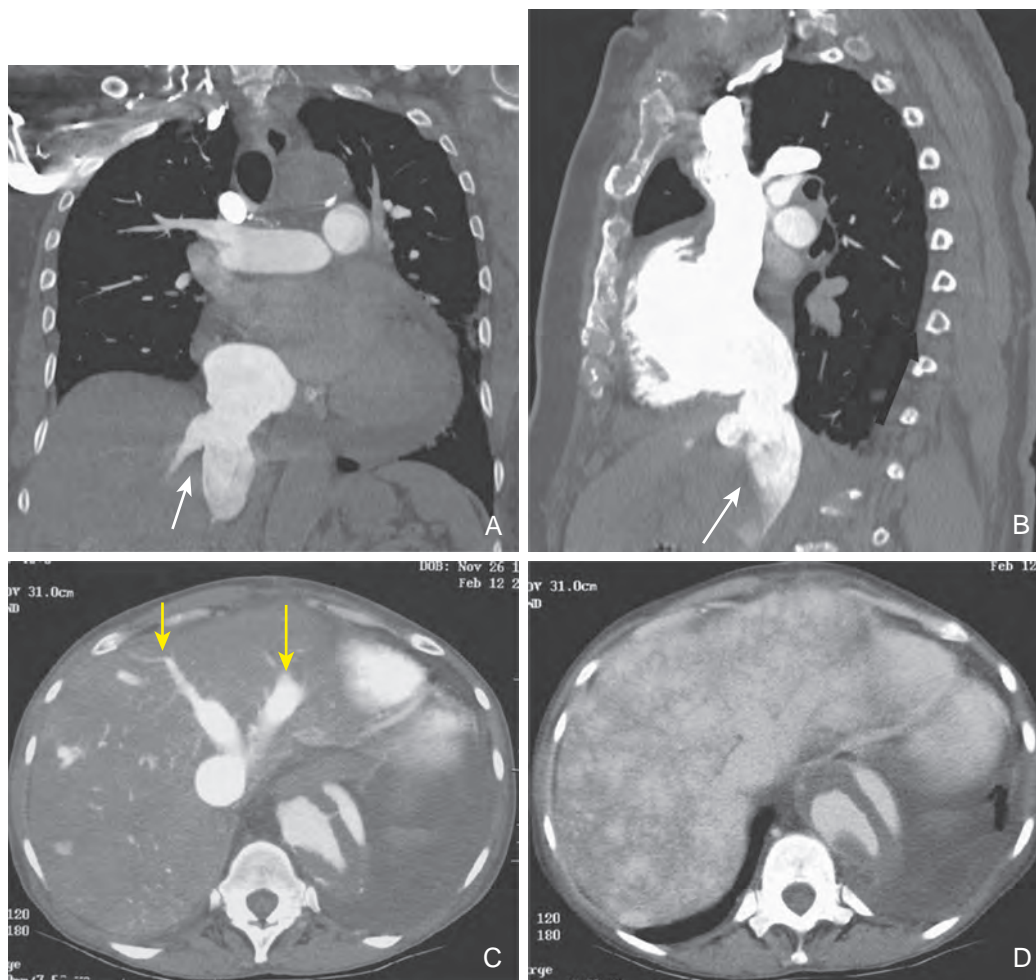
Passive hepatic congestion: CT features. Coronal (A) and sagittal (B) reformatted MDCT images demonstrate reflux of contrast material into a dilated inferior vena cava (arrows) and hepatic veins. C. Axial scan in a different patient with a dissecting thoracoabdominal aortic aneurysm shows a dilated inferior vena cava and hepatic veins (arrows). D. Delayed image of patient shown in C reveals a mottled enhancement pattern typical of passive hepatic congestion.
